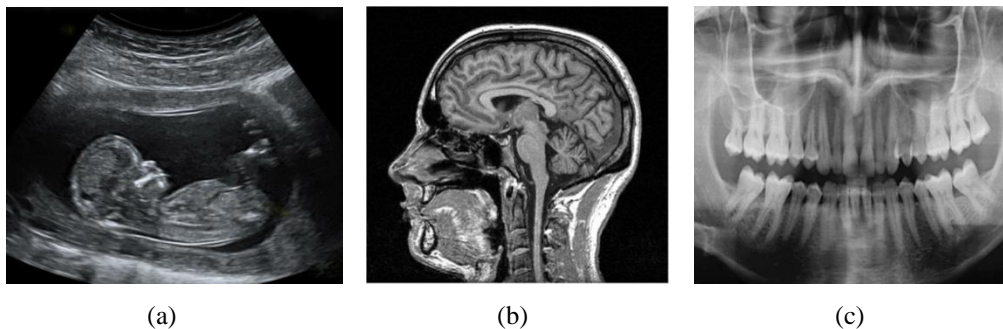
1: Examples of different types of medical images (a) US image of fetal (b) MRI of the brain (c) X- ray of the teeth
